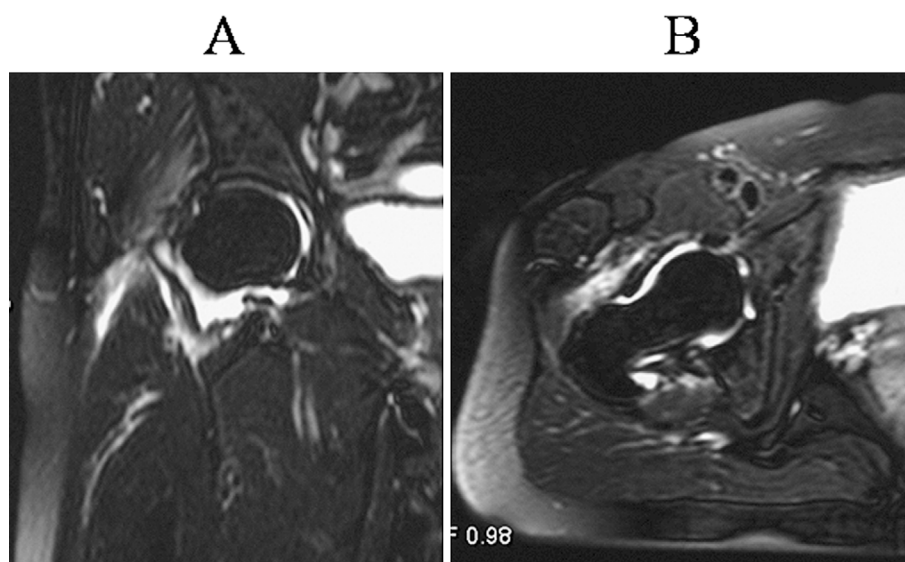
Magnetic resonance imaging scans obtained during the patient's first febrile attack. Fat suppression T2-weighted (FS-T2W) images in the coronal (A) and axial (B) planes show high signals in the right hip joint. The findings suggest the presence of joint effusion and thickened synovium. High signals are also seen in the soft tissues around the joint, thus reflecting inflammatory changes.
